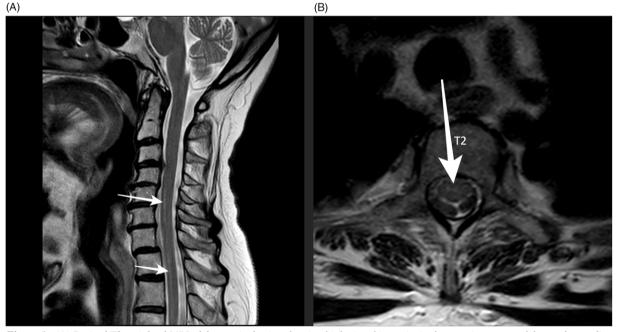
(A) Sagittal T2-weighted MRI of the cervical spine showing high-signal intensity in the anterior aspect of the cord extending from C5 to T4 without the evidence of edema (white arrows). (B) Axial T2-weighted MRI of the spine at T2 level showing slight high-signal intensity in the anterior aspect of the spinal cord (white arrow).
